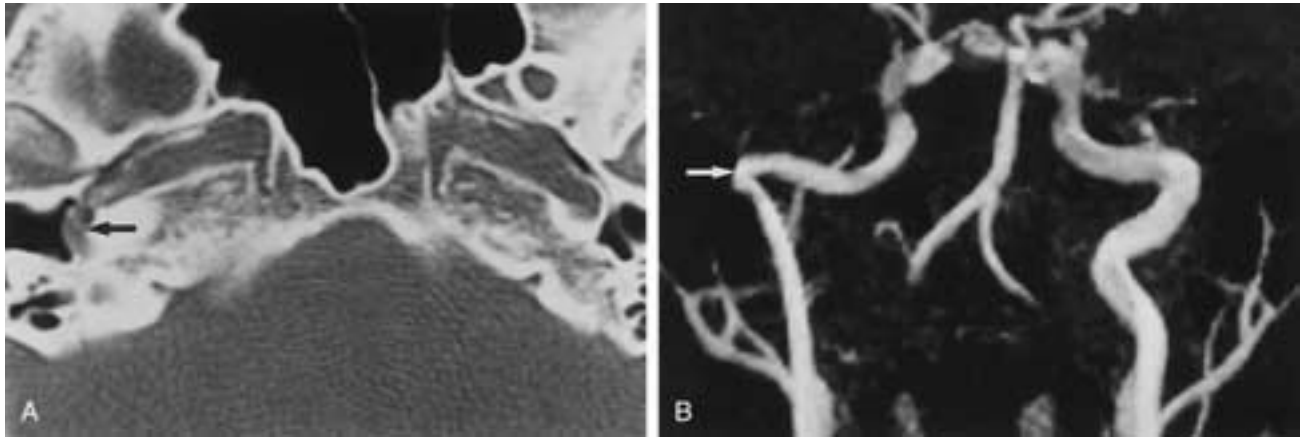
Right aberrant carotid artery. A, High-resolution CT. The arrow indicates an aberrant artery coursing through the right tympanic cavity to enter the horizontal carotid canal through a dehiscence in the carotid plate. B, MRA 3D time-of-flight technique, maximum intensity projection, shows the typical sharp bend of a narrow aberrant artery (*arrow*) through the tympanic cavity.
